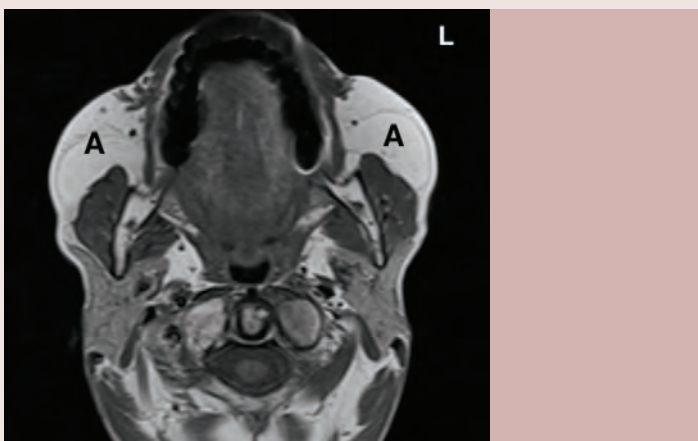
MRI T1 Axial. Increased fat (A) at level of maxillary dentition.
